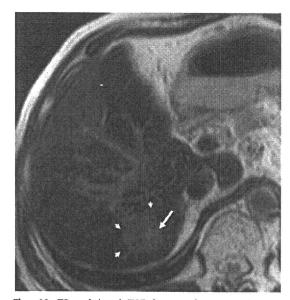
T2-weighted TSE image shows an iso- to slightly high-signal—intensity nodule (*arrowheads*) with a focus of higher signal intensity (*arrow*) within the nodule. This higher signal intensity focus within the nodule shows the presence of HCC.
